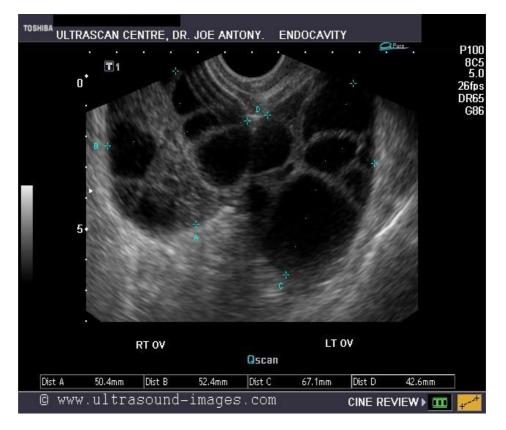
Transvaginal ultrasound images of ovarian hyperstimulation
